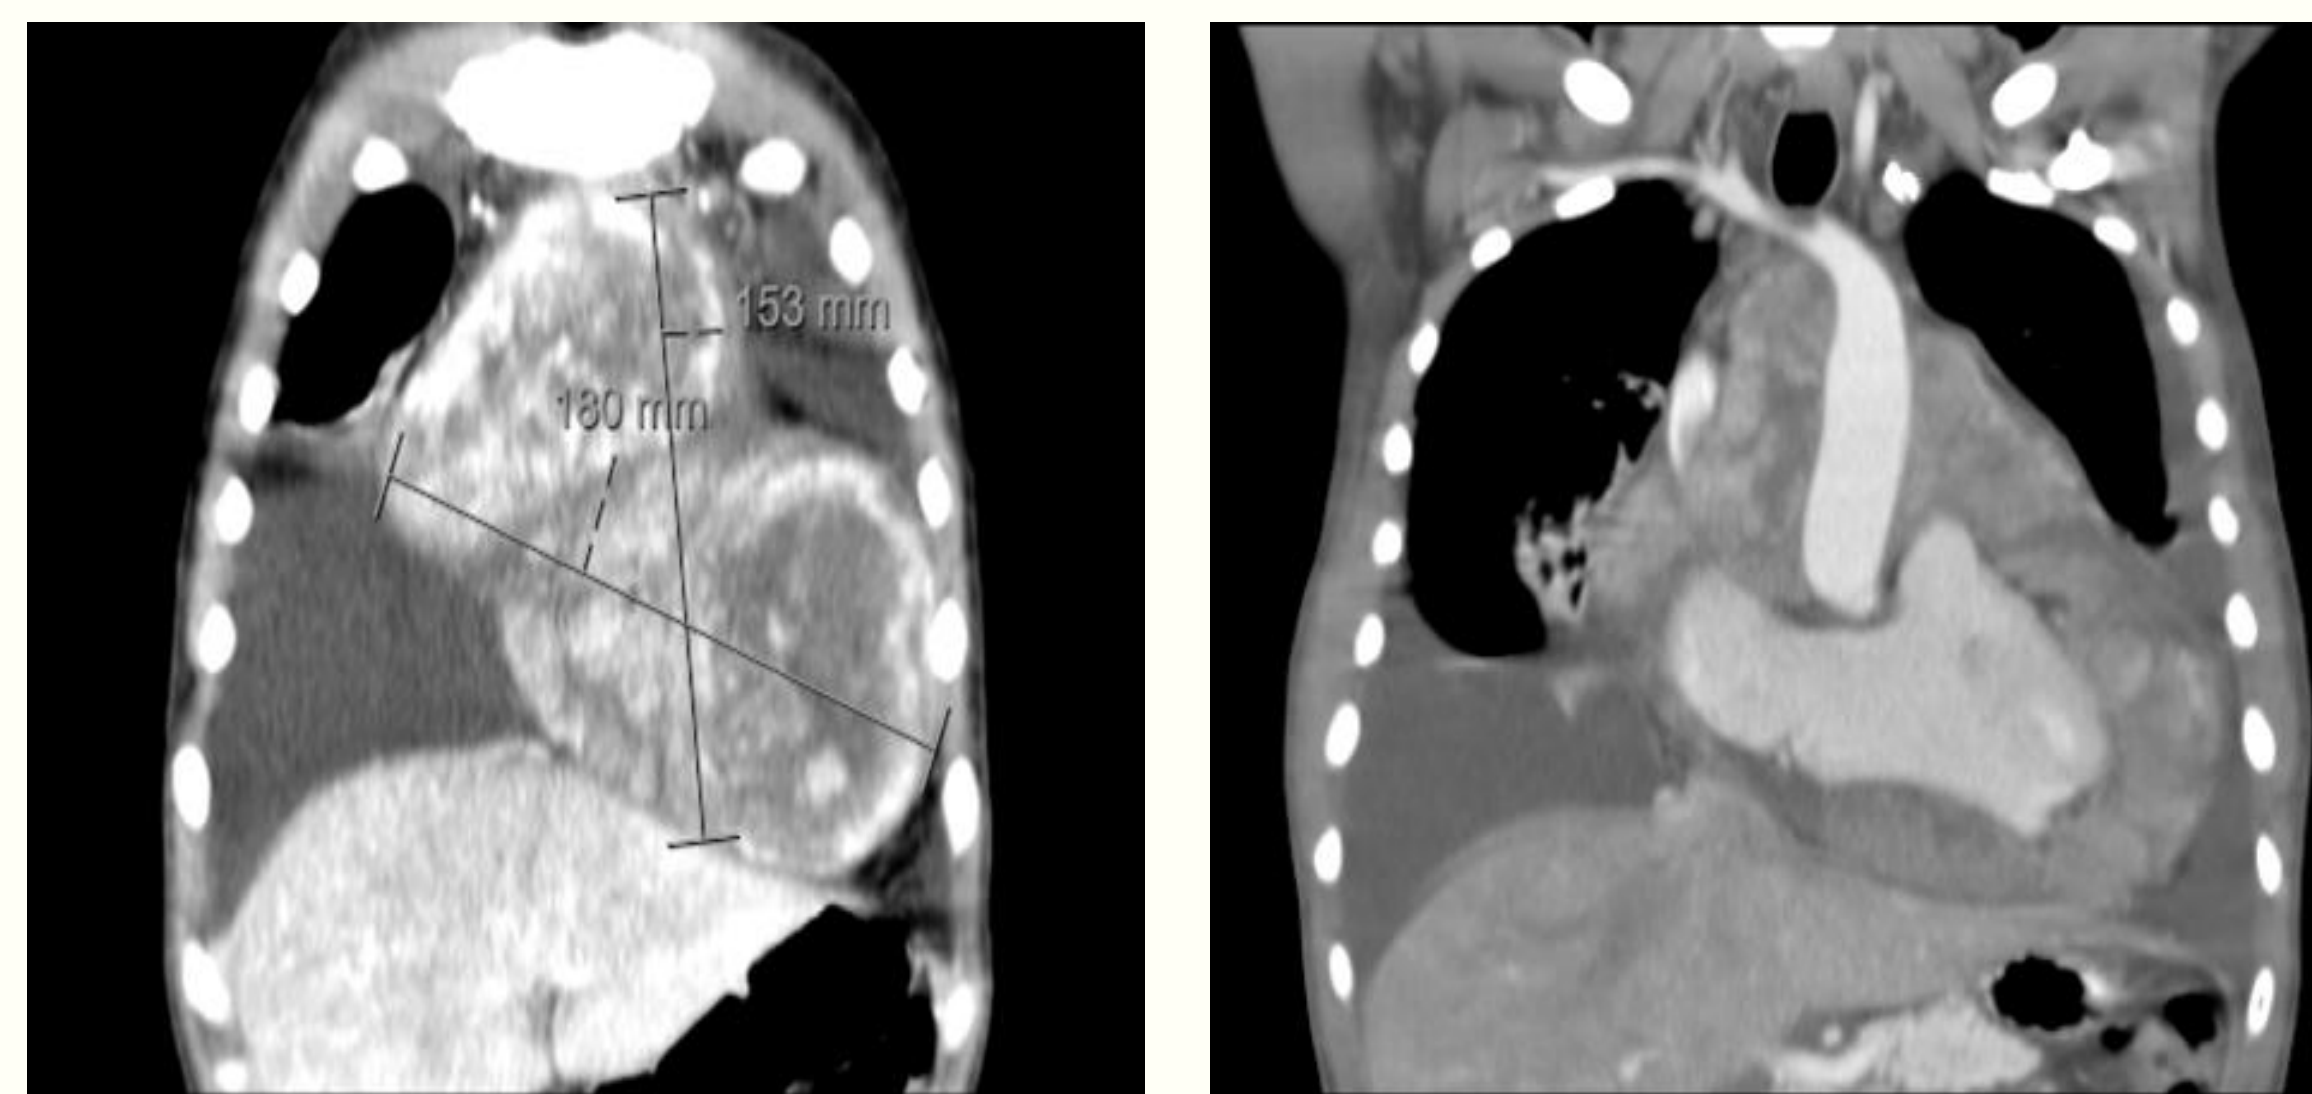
Admission Chest CT showing large infiltrative mass with varying degrees of enhancement
